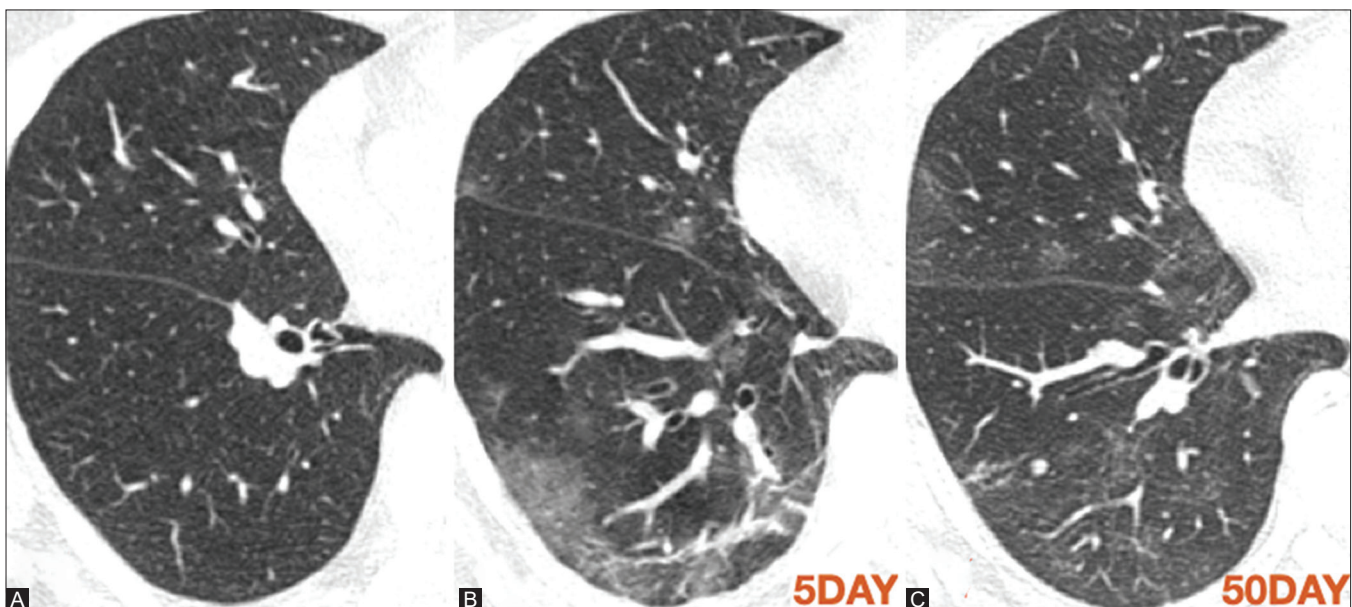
(A-C): (A) HRCT early in disease reveals no abnormality (stage I). (B) HRCT later 5 days later reveals typical subpleural ground-glass densities with reticular bands. Follow up HRCT (C) on day 50 from first scan reveals clearing of opacities with few residual ground-glass densities
